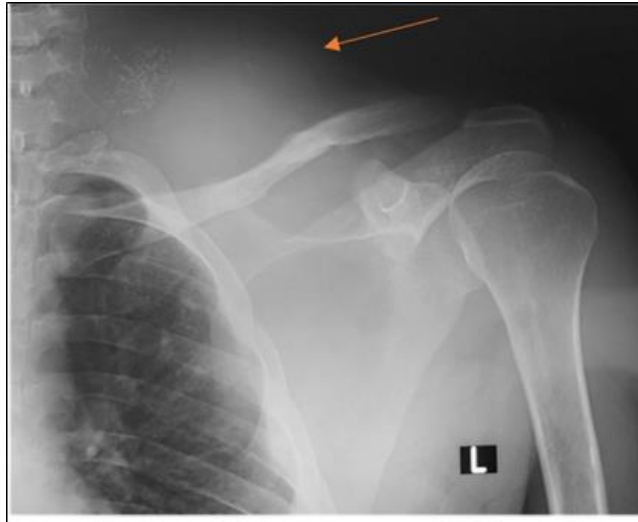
X-ray of the shoulder: contour of the mass depending on the soft tissues and malunion of the clavicle
